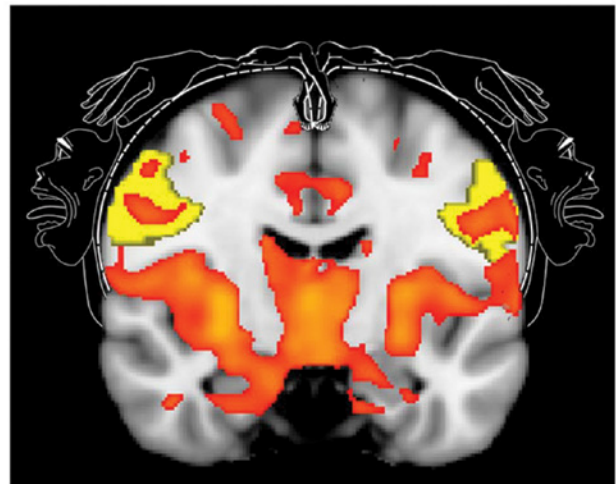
Image showing cerebral blood flow changes — the processing of pain — following tooth extraction. Changes are shown as they relate to the classical representation of the jaw. Reprinted with permission from Howard M, Krause K, Khawaja N. Beyond patient reported pain: perfusion magnetic resonance imaging demonstrates reproducible cerebral representation of ongoing post-surgical pain. *PLoS One*. 2011;6(2):e17096. doi:10.1371/journal.pone.0017096.g002.
